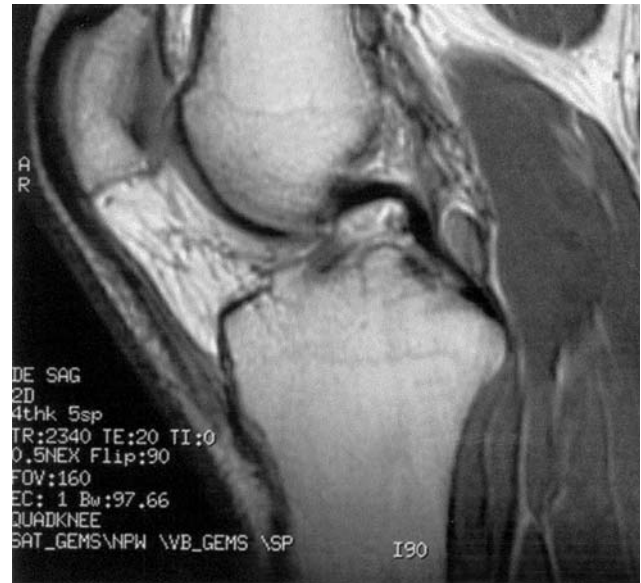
Sagittal MRI image of distal patellar tendinosis with thickened distal patellar tendon
